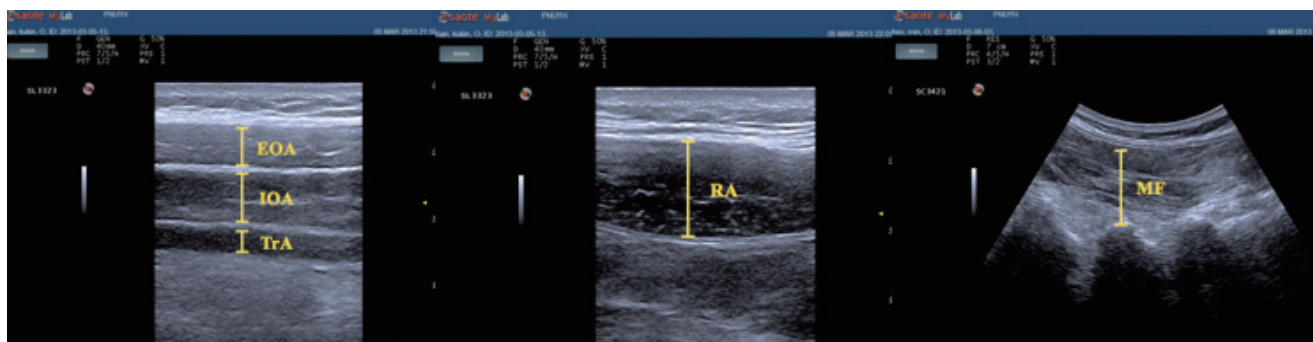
Picture of measuring the trunk muscle thickness using ultrasonography.
